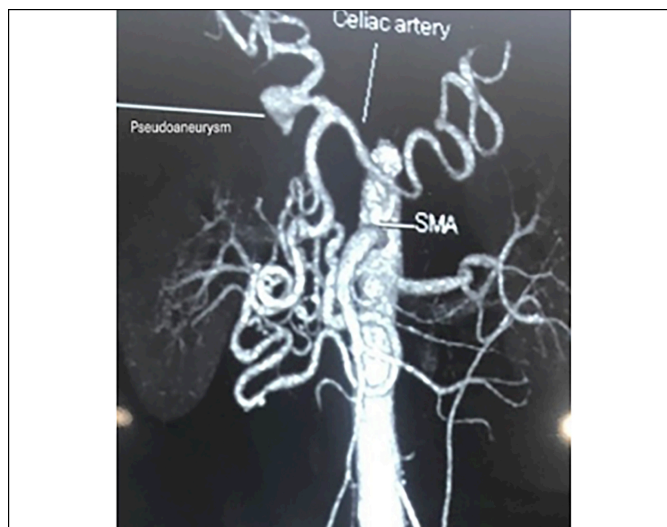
CT angiogram showing hepatic artery pseudoaneurysm.
